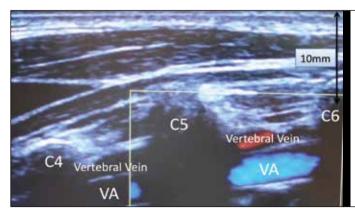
The vertebrae, vertebral vein and artery. On moving the probe cephalad, the VA ran parallel to the skin and between the C4 and C6 vertebrae in the longitudinal view. Before puncturing the IJV, the positions of the VA and arteries branching from the TCT in addition to the common carotid artery (CCA) may be ultrasonographically identified to avoid inadvertent arterial puncture. The VA sometimes seems difficult to be identified in adults, and the TCT can be mistaken as the VA. In young volunteers, the SCA can be identified 15–65 mm above the clavicle. Identifying the SCA first, TCT second and VA last may facilitate confirming the position of the arteries around the IJV.
